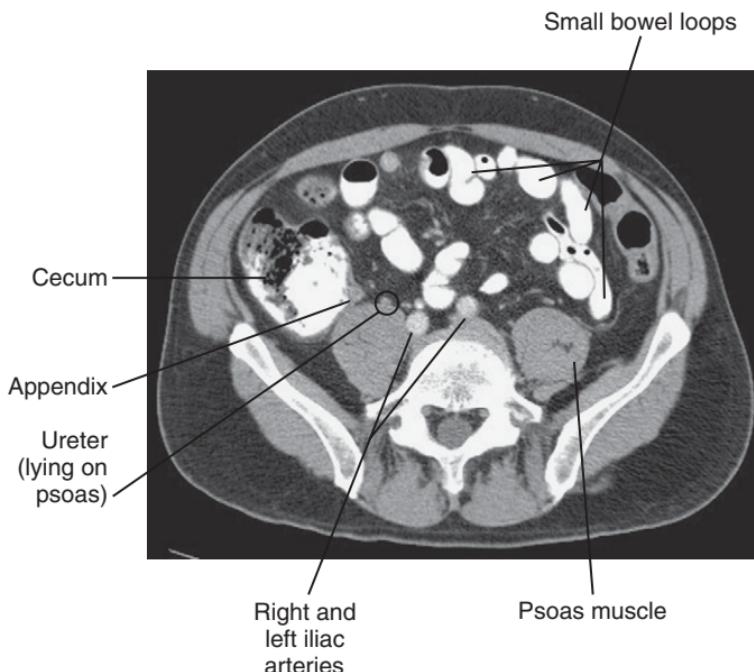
Normal CT focusing on lower abdomen/pelvis.
